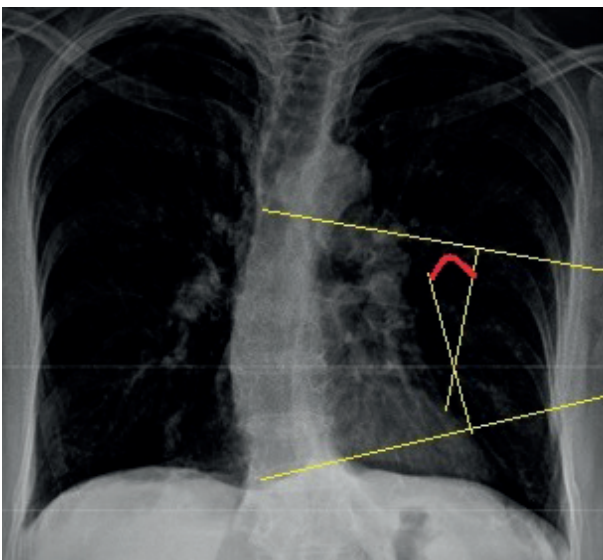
Chest X-ray showing thoracic scoliosis with a Cobb angle of 19 degrees.
